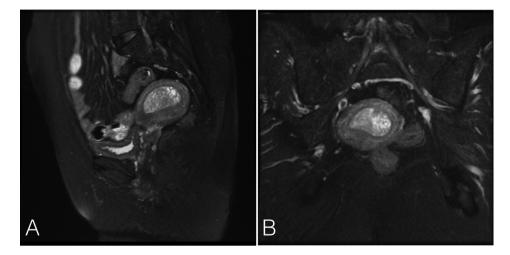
Magnetic resonance image of the adenomyoma showing an endometrial mass. (A) Sagittal T2-weighted image; (B) transverse T2-weighted images. Endometrial tumors have a multiloculated cystic appearance and soft tissue components.
